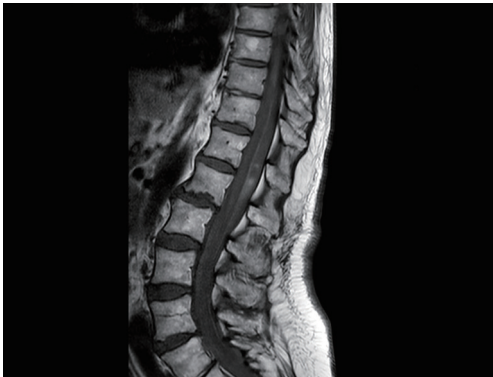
MRI (T1 sequence, sagittal) showing a spinal subarachnoid hemorrhage, with blood from the level of thoracic vertebrae 6 to the sacral and with ventral displacement of the spinal cord without signs of myelopathy. MRI, magnetic resonance imaging.
